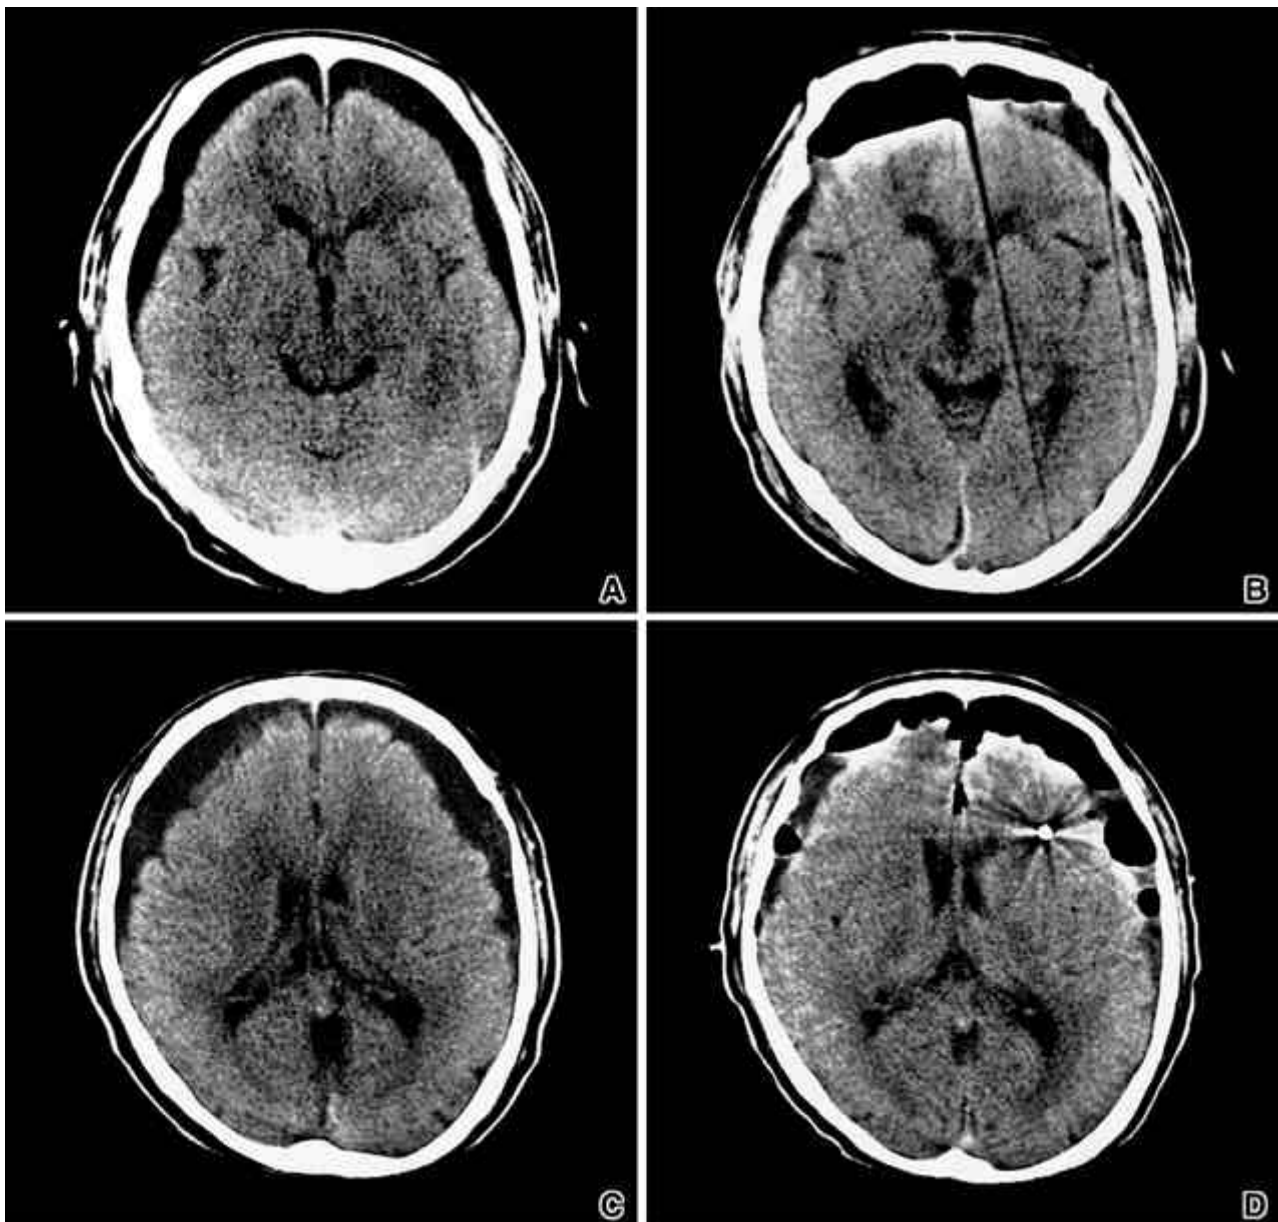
Pre (A, C)- and post (B, D)-operative (burr-hole drainage) CT scans of a 76 years old male (A, B) and a 65 years old male (C, D) patients with SDG show air instead of fluid in the subdural space. The size was not reduced in both cases.
